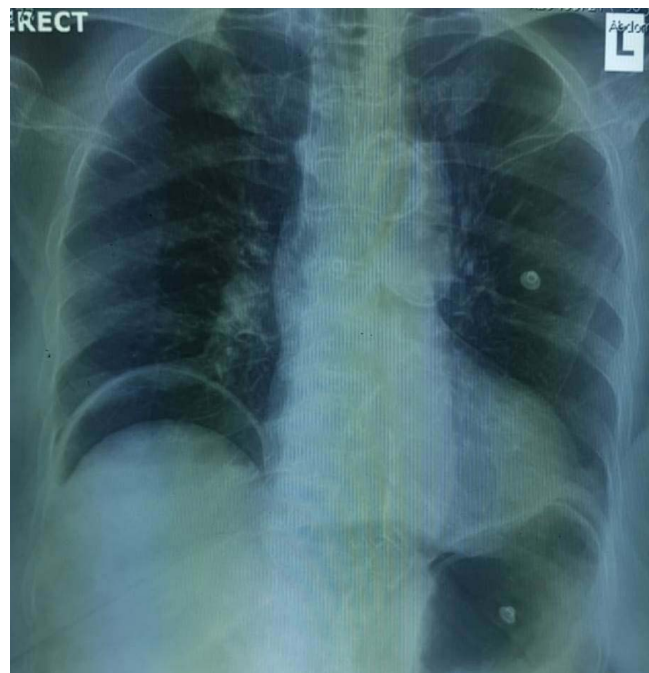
Erect chest X-ray PA view showing free air under right dome of the diaphragm.
